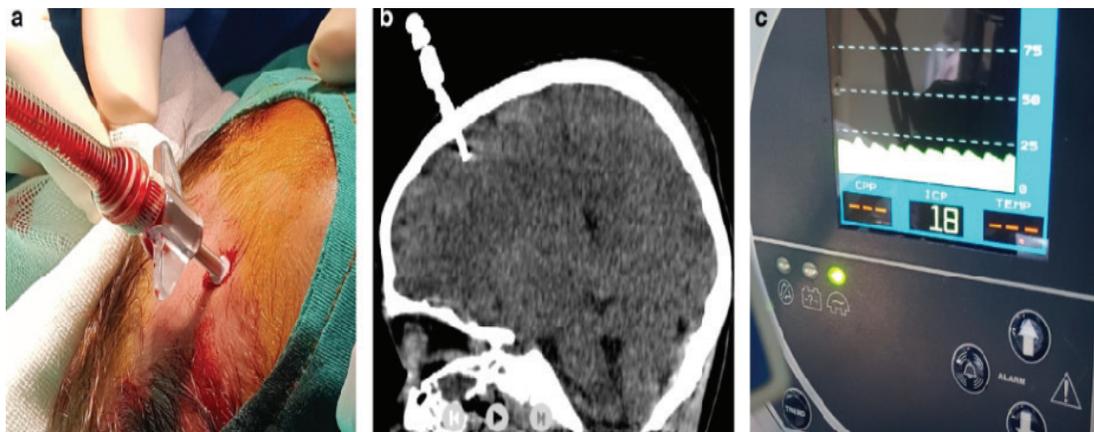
a) Image revealing that ICP monitoring catheter is implanted to the right Kocher point of the patient. b) Sagittal non-enhanced cranial CT image showing implanted ICP monitoring catheter. c) ICP monitor revealing the ICP value of 18 mmHg
